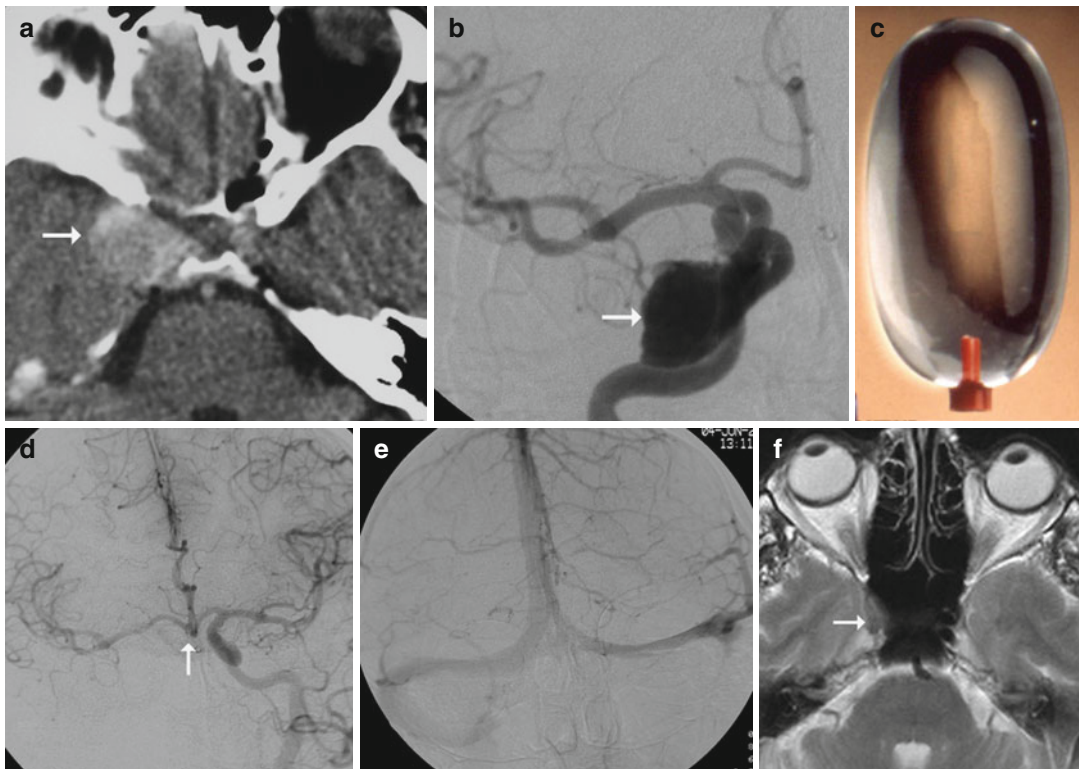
Permanent balloon occlusion of the Internal Carotid Artery because of intracavernous giant aneurysm. (a) Postcontrast cranial CT. The right cavernous sinus is inflated, the inhomogeneous contrast enhancement indicates the giant aneurysm within it (arrow). (b) DSA, the right ICA contrast angiography depicts the giant aneurysm (arrow). (c) Detachable microballoon used for vascular occlusion (DSB balloon, Boston Scientific, Fremont, CA, USA). (d) Test occlusion. DSA, left ICA contrast angiography and right ICA balloon occlusion, arterial
